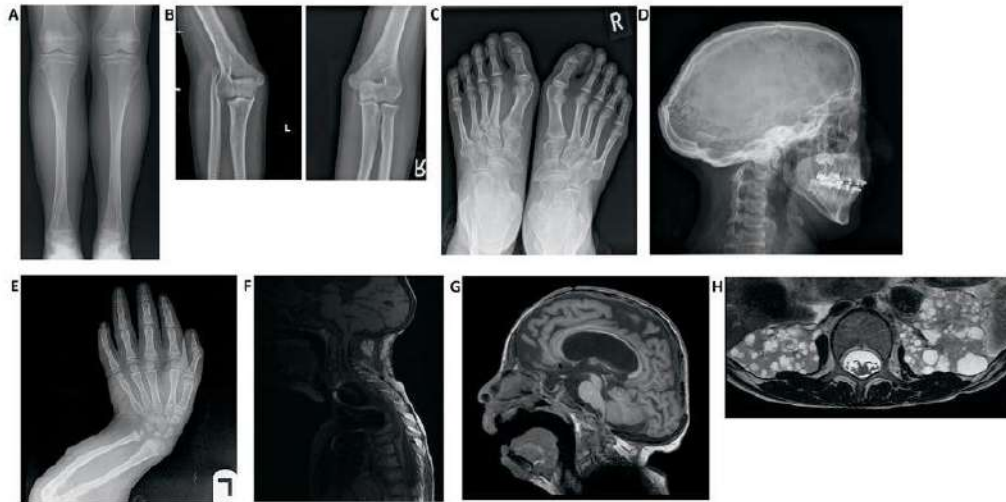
Imaging findings in patients with Hajdu–Cheney syndrome. (A) Radiograph of the frontal view of the tibia and fibula. Note the elongated and medially deviated fibula, superposing the tibia bone, referred to as a “serpentine fibula”. (B) Radiographs of the lateral view of the left arm showing dislocation of the radial head. (C) Radiograph of the frontal view of the feet showing hallux valgus, crowded metatarsal bones, short foot distal digits, and acroosteolysis signs at distal phalanges of the first digit. (D) Radiograph of the lateral view of the skull, demonstrating batrocephaly, frontal sinuses hypoplasia, and multiple occipital wormian bones. (E) Radiograph of the frontal view of the hands, showing crowded metacarpal bones, short hand distal digits, and acroosteolysis signs at the distal phalanges. (F) Radiograph of the lateral view of the arm, showing shortening of the distal fingers and long bones of the arm, and a curved radius and ulna. (G) Spinal MRI showing deformations of the cervical spine, as well as a significant syrinx of the cord. (H) Brain MRI. Note the ventricular enlargement with a VP (ventriculo-peritoneal) shunt, frontal hypoplasia of the sinuses, and a small foramen magnum. (H) Abdominal MRI showing multiple bilateral kidney cysts.
